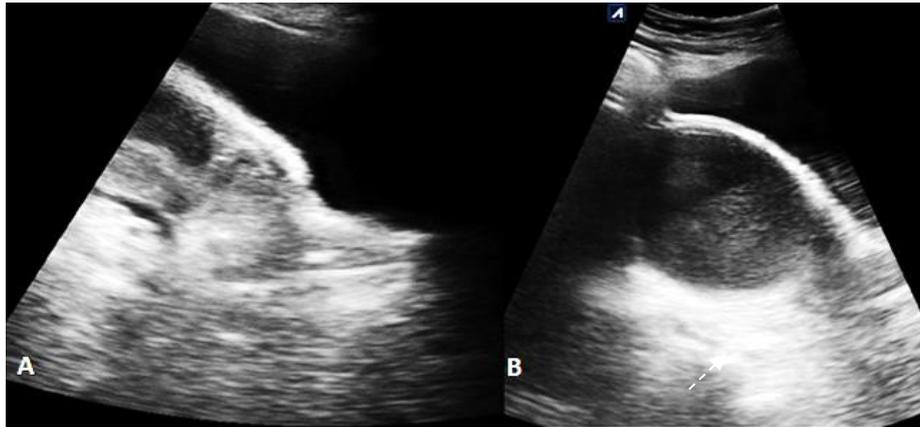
(A)(B) Greyscale ultrasound images of the pelvis showing bulky cervix with a heterogenous hypoechoic mass lesion replacing cervix involving lower uterine segment and upper vagina. An anechoic collection is noted in the endometrial canal.
